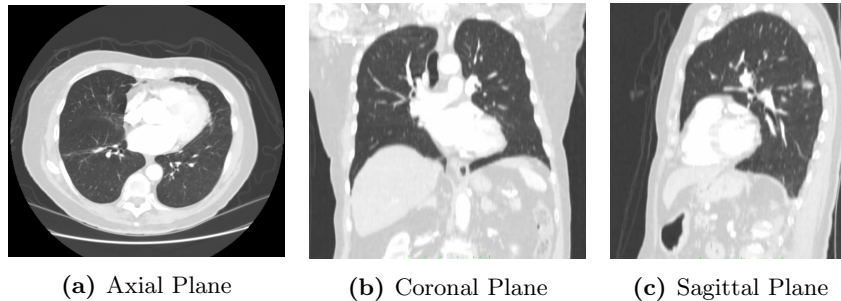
Planes captured in a Computed Tomography (CT) scan.
